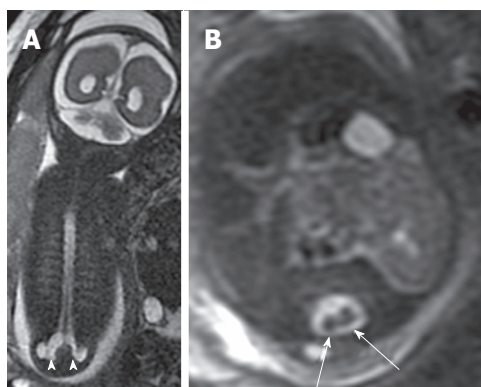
Lumbar meningocele. Coronal (A) and axial (B) T2 weighted magnetic resonance images of a 26 wk fetus demonstrate complex spinal anomalies with a lumbar meningocele (arrowheads) and diastematomyelia (arrows).
